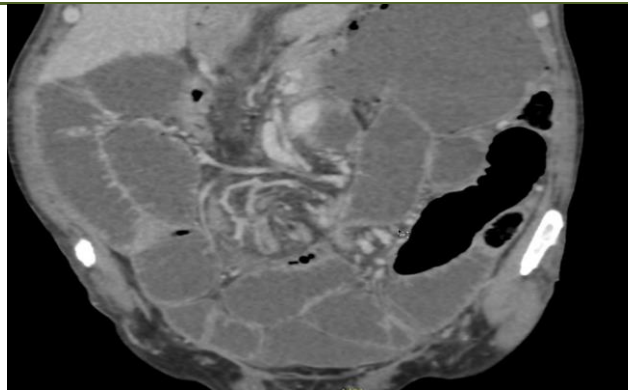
Frontal CT section showing the turn/ whorl sign
